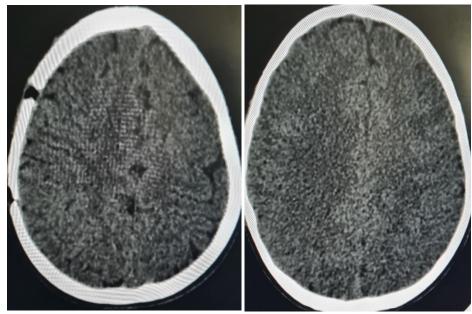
Spontaneous contrast axial slice brain CT: Complete regression of the extradural hematoma with right parietal bone defect in relation to the operative procedure
